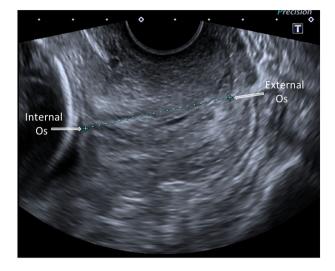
Transvaginal ultrasound cervical length of $45\,\mathrm{mm}$ with good technique.
